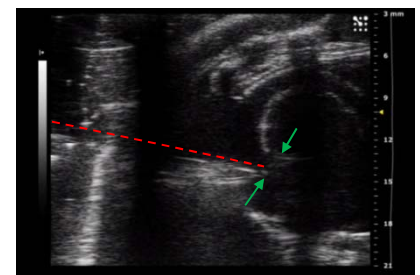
Snapshot from ultrasound guided injection. Red line runs parallel to needle echo and green arrows define the epi/endocardial border.
